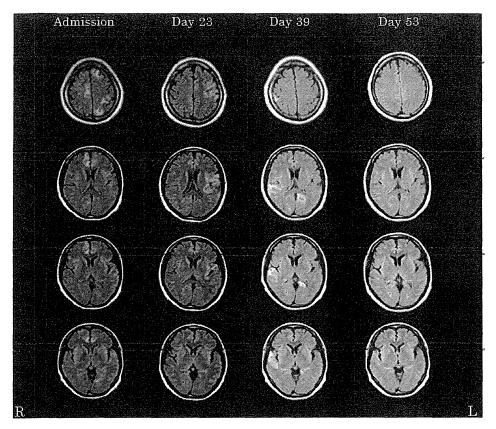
Fluid-attenuated inversion recovery (FLAIR) MRI of the brain. High-intensity areas showed various changes with time after onset.
